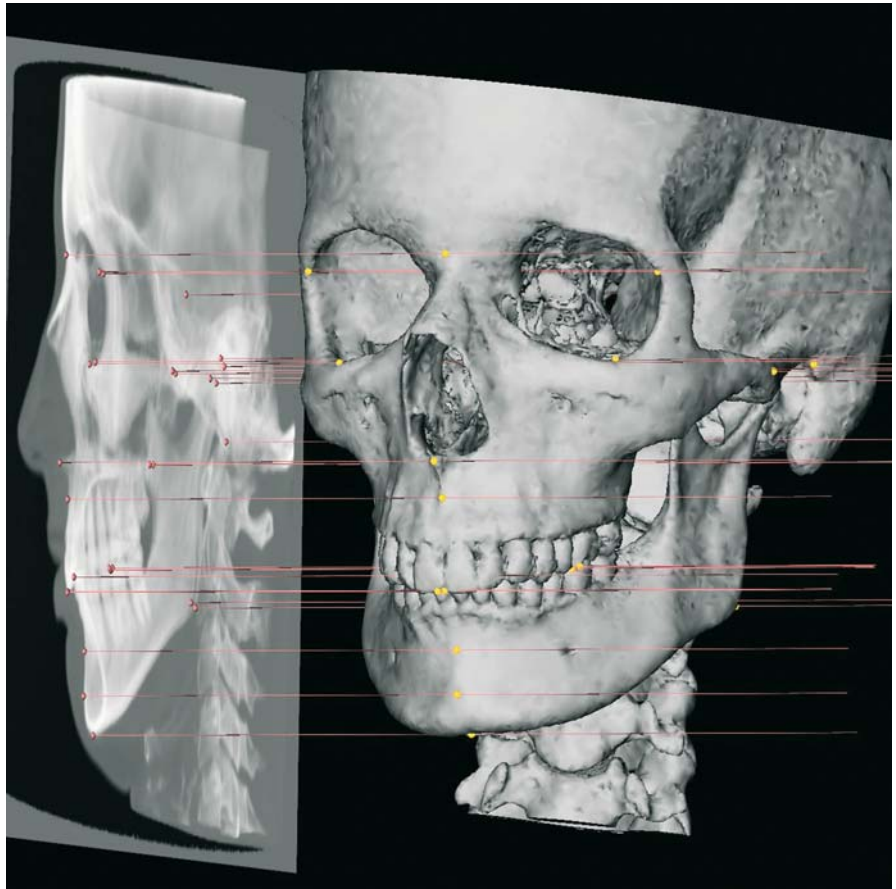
a–d. Set-up of 3-D cephalometric hard tissue landmarks. (3-D CT, patient K.C.)
